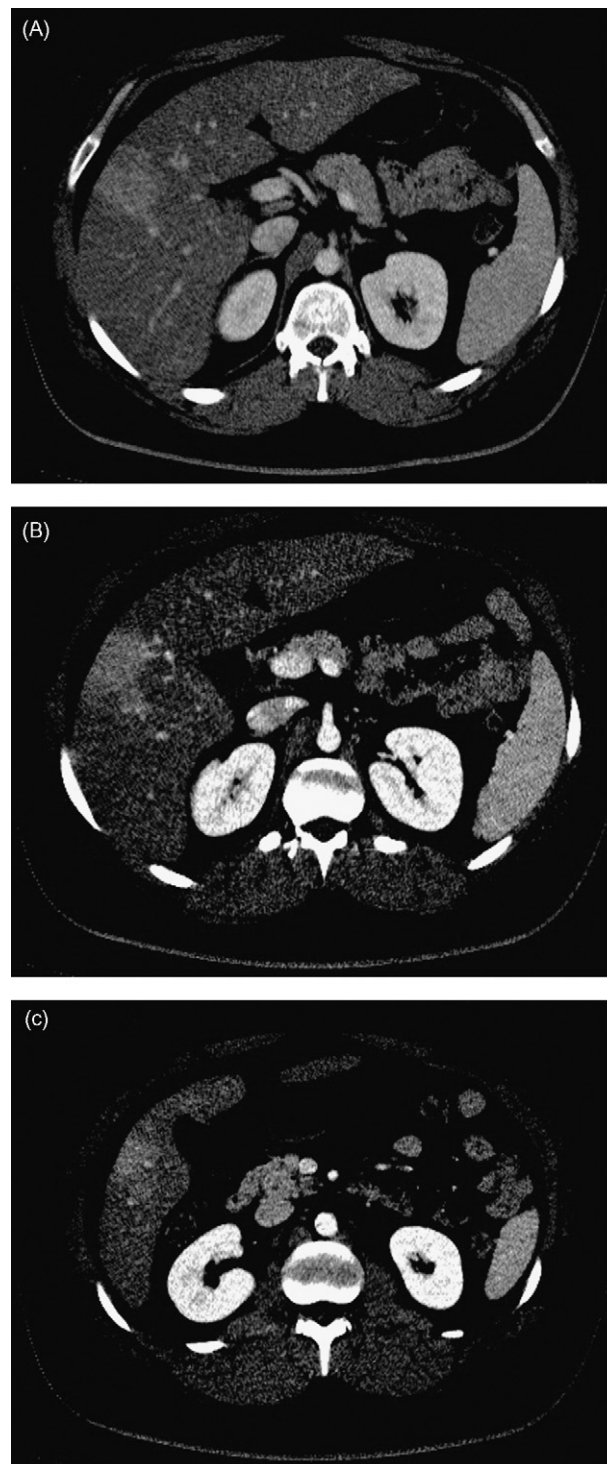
Enhanced CT arterial phase liver window: (A) the celiac artery level, (B) the level of the superior mesenteric artery SMA, and (C) below the level of the SMA origin showing a region of blush within the right lobe.
